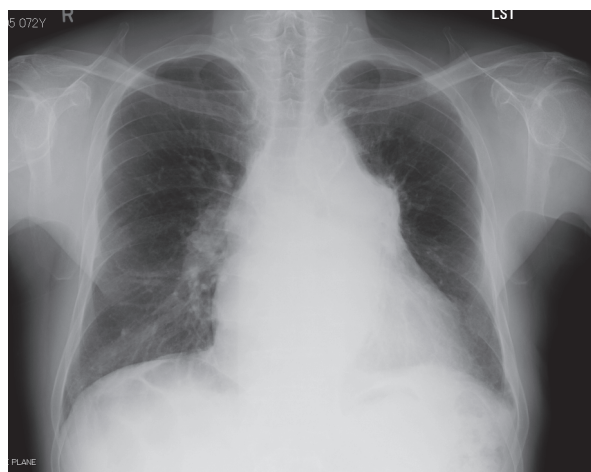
Chest radiograph finding showing enlargement of the left hilar region and cardiomegaly
